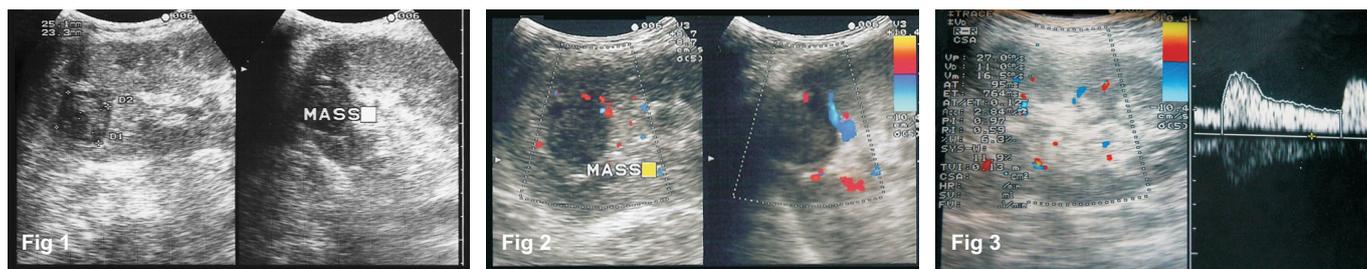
A 25×23 mm Hypoechoic lesion on sonography
